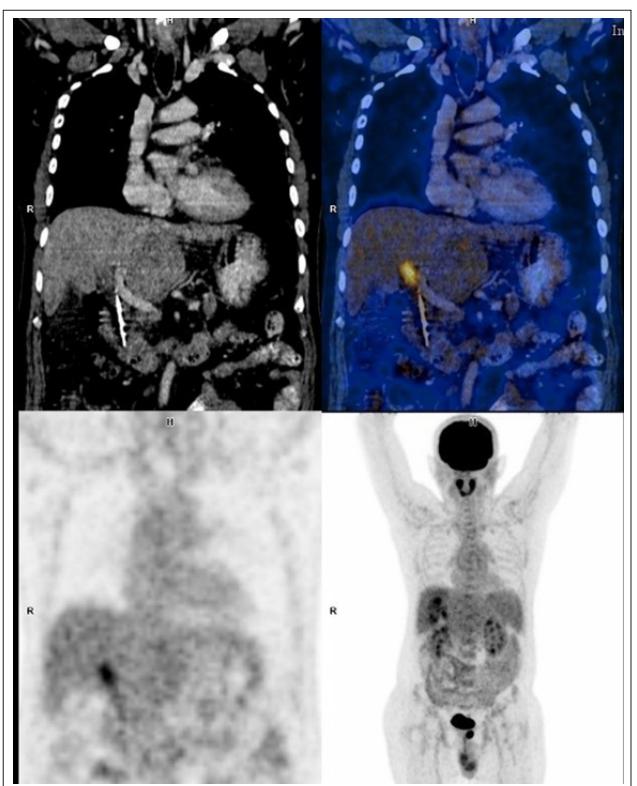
FDG PET Scan Showing Avidity (SUV max 4.8) in the Right Branch of Portal Vein (Coronal)
